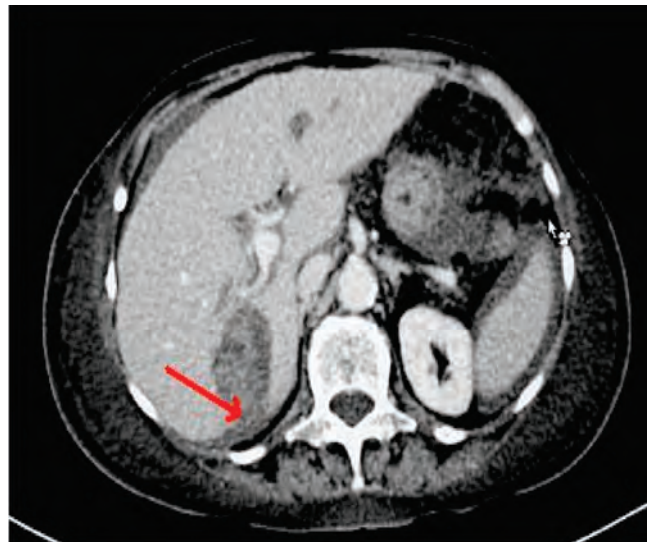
CT: hematoma rupture and extravasation into the peritoneal cavity (arrow).
